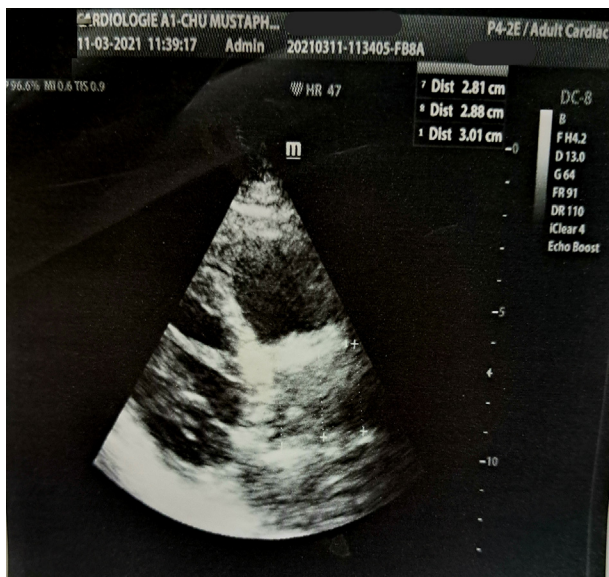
The parasternal long-axis view of the transthoracic echocardiography showed an ascending aorta of normal size with increased echogenicity of its wall.
